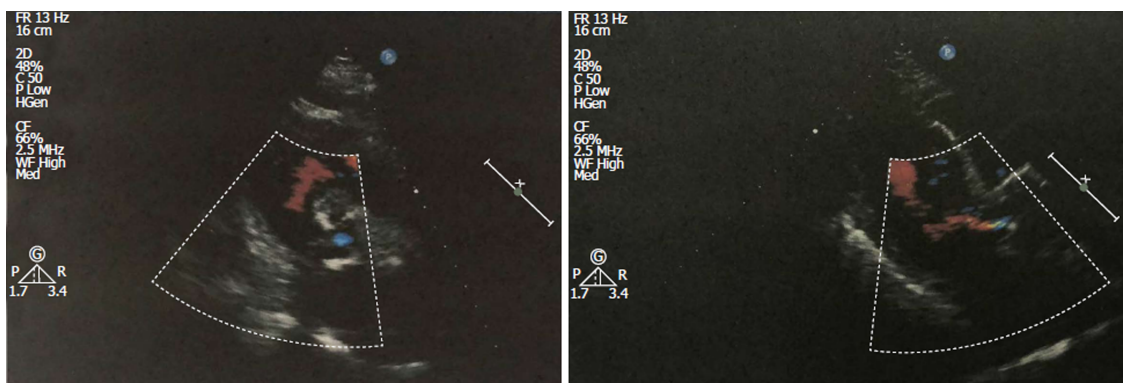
Echocardiographic examination on October 28, 2017.
